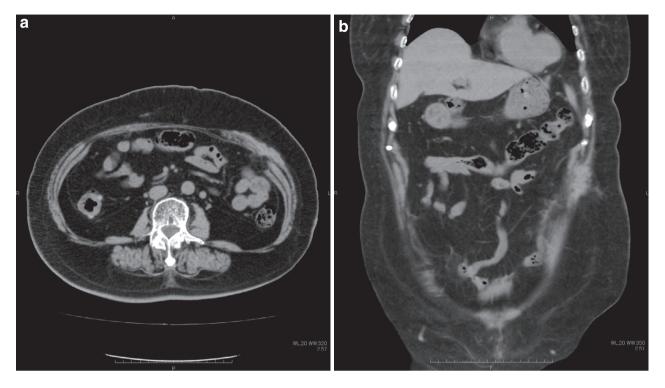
Findings of CT at postoperative 1-year follow-up. (a) Axial section. (b) Coronal section.
